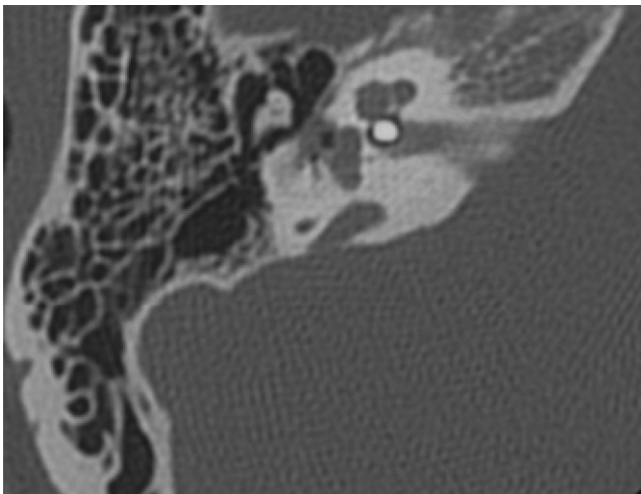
Computed tomography scan on the right temporal bone.
